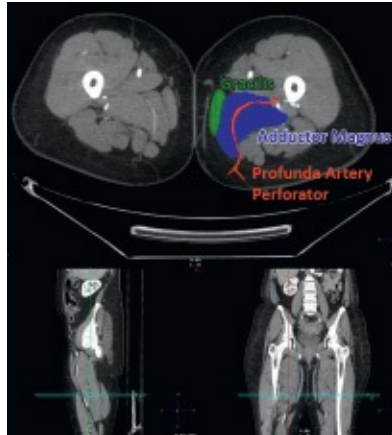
• CTA of the lower extremity identifying the location of the profunda artery perforator behind the gracilis traversing the adductor magnus toward the profunda femoris artery.
